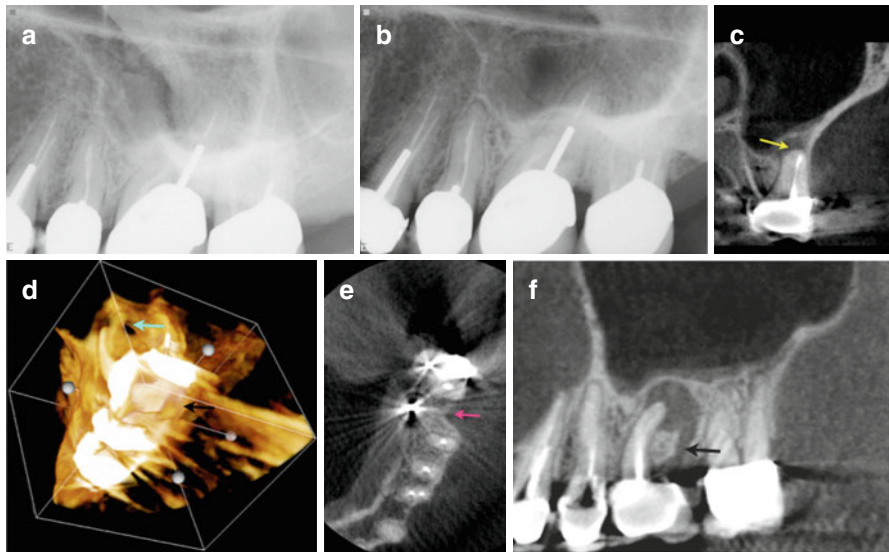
Periapical radiographs of tooth #14, mesial and distal angles, respectively (a, b). Coronal view of the mesiobuccal root showing a missed mesiobuccal canal and periapical pathology not detected on the 2D radiograph (*yellow arrow*) (c). 3D reconstruction showing a crestal bony defect (*blue arrow*) (d). Axial view showing a previous distobuccal root amputation site (*pink arrow*) that was not detected on the periapical radiographs (e). (f) Sagittal view showing the crestal defect (*black arrow*) communicating with the periapical lesion and elevating the floor of the maxillary sinus, with no evidence of sinus perforation (f)
